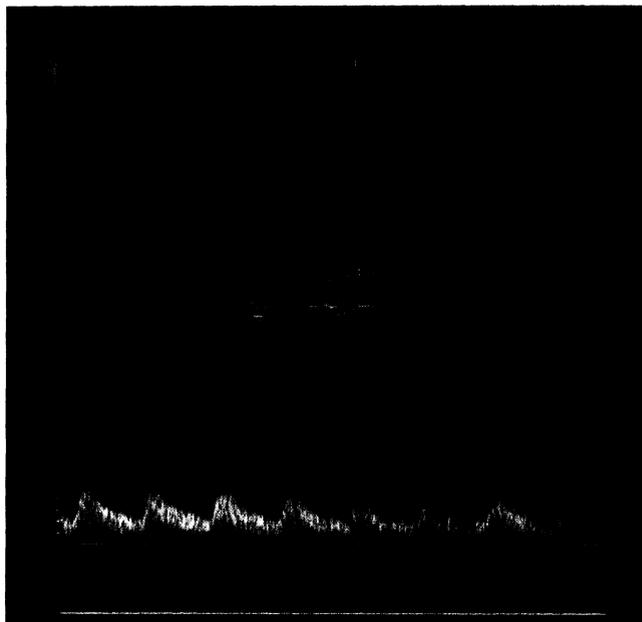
Pulsed Doppler tracing of umbilical artery showing caliper placement at peak systole and end diastole, to calculate an S/D ratio.
